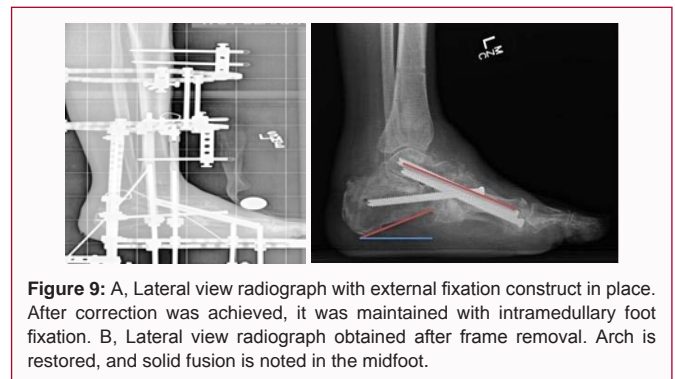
A, Lateral view radiograph with external fixation construct in place. After correction was achieved, it was maintained with intramedullary foot fixation. B, Lateral view radiograph obtained after frame removal. Arch is restored, and solid fusion is noted in the midfoot.
